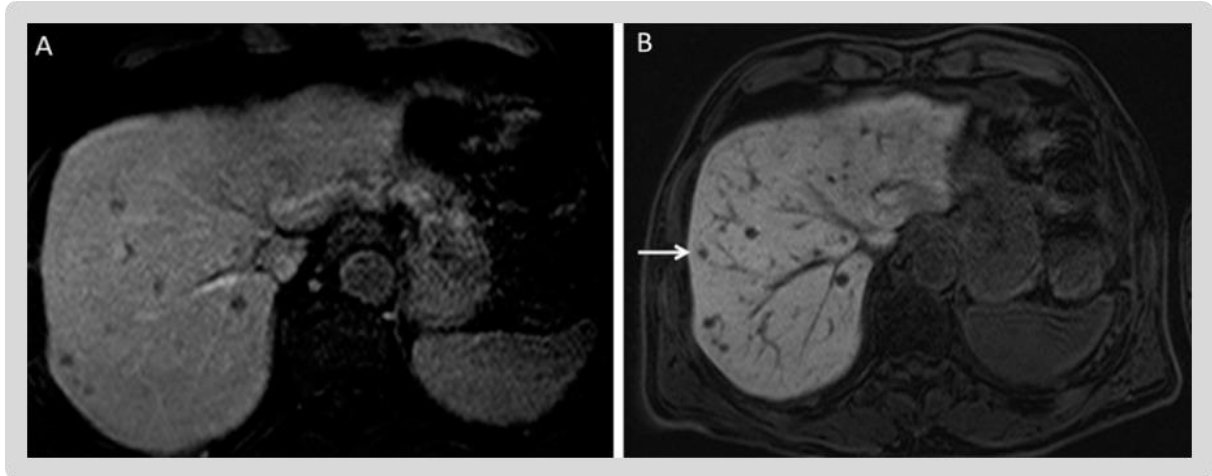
MRI image. A) Demonstration of multiple hypodense lesions concerning metastases. B) Post-contrast image demonstrating several other lesions in addition to the previously seen lesions (arrow). (Image sourced from Balasubramanya et al. 2016).
